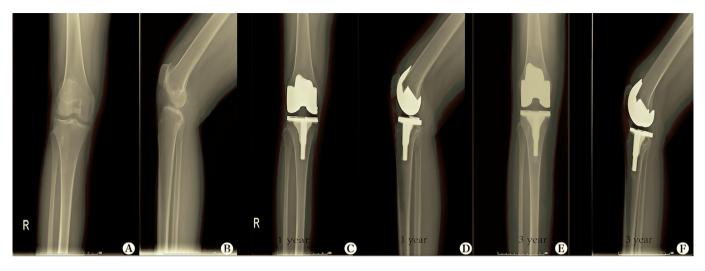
X-rays of the total knee arthroplasty. (A) Preoperative anteroposterior X-ray of the total knee arthroplasty. (B) Preoperative lateral X-ray of the total knee arthroplasty. (C) Postoperative anteroposterior X-ray of the total knee arthroplasty taken at 1 year. (D) Postoperative lateral X-ray of the total knee arthroplasty taken at 1 year. (E) Postoperative anteroposterior X-ray of the total knee arthroplasty taken at 3 years. (F) Postoperative lateral X-ray of the total knee arthroplasty taken at 3 years. (F) Postoperative lateral X-ray of the total knee arthroplasty taken at 3 years. The X-rays showed a good position of the prosthesis with no loosening at 1 and 3 years postoperatively.
